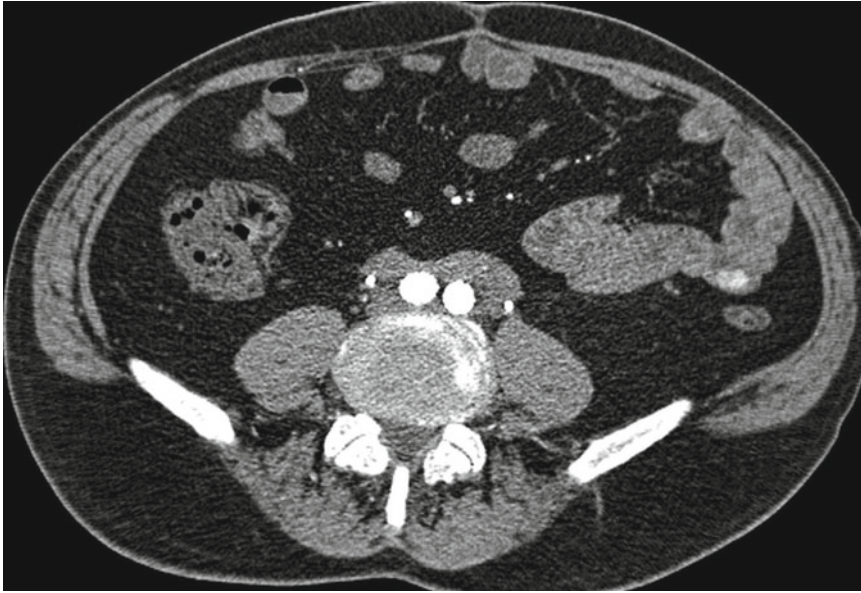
Computed tomography of pelvis demonstrating retroperitoneal fibrosis surrounding the common iliac vessels and ureters. The ureters appear as contrast filled structures at the lateral edge of the fibrotic mass
